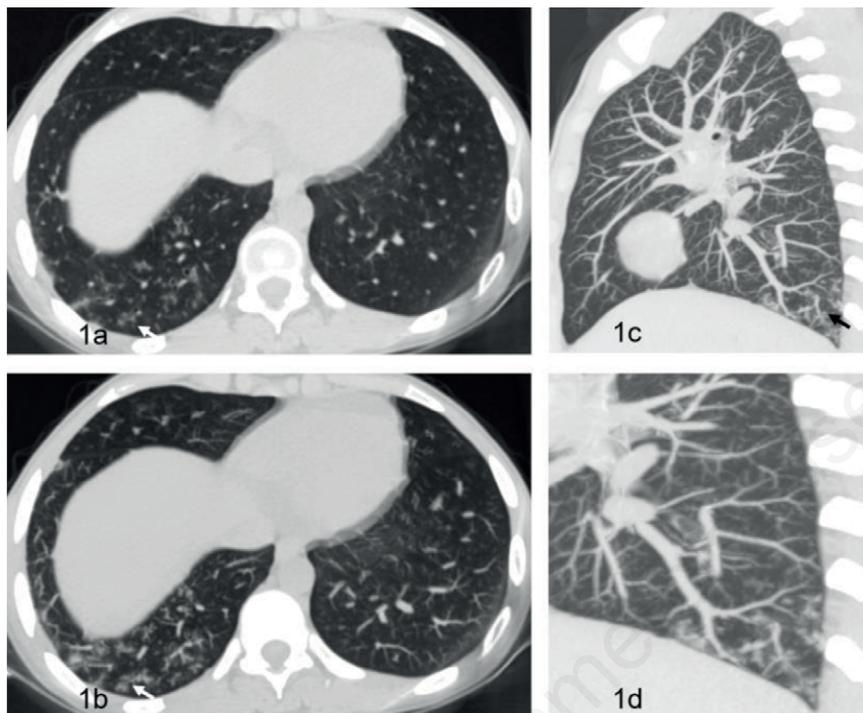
A 54-year-old male with dermatomyositis disease on high dose long-term corticosteroids presented with cough. High-resolution CT chest showed. a) On axial thin section CT image, ground glass density centrilobular nodules with fuzzy margins (white arrow) are noted in the right lower lobe basal segments. b) Axial MIP image at the same level further accentuates the tree-in-bud opacities with triangular-shaped tips (white arrow). Note the density of the nodules is less than the adjacent vessels. c) Sagittal reformatted MIP image shows tree-in-bud opacities with feathery fern leaf-like branching nodules in the posterior basal segment (black arrow). d) Magnified MIP sagittal image clearly demonstrates the feathery fern leaf-like pattern. BAL Galactomannan was positive suggestive of invasive aspergillosis.
